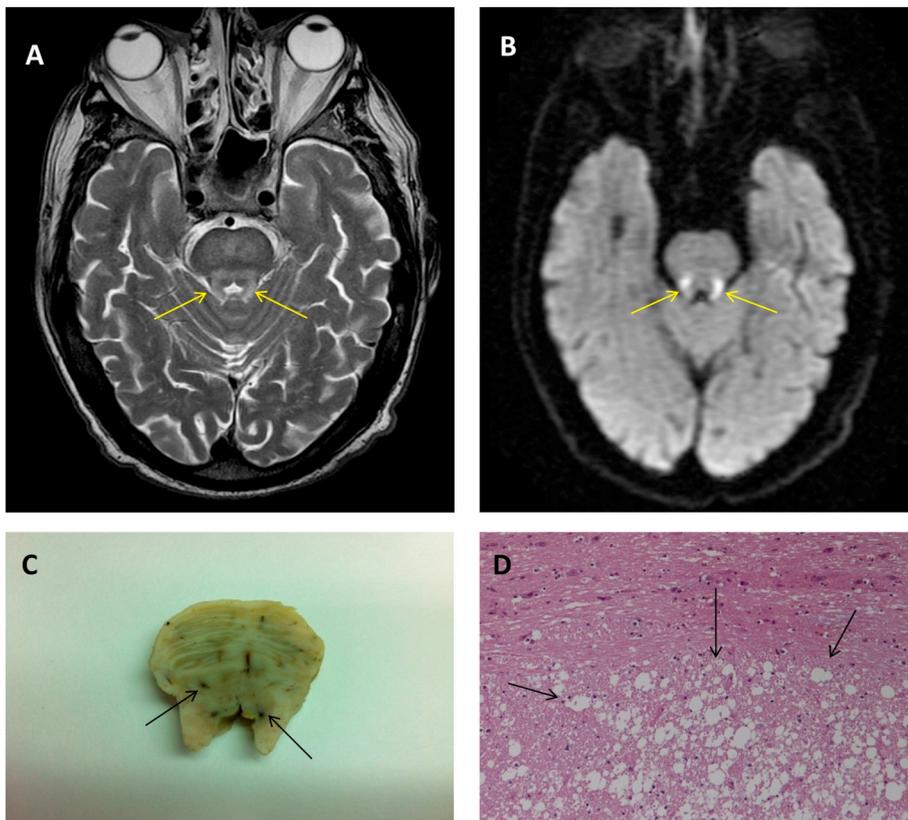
Brain magnetic resonance imaging axial sections and neuropathology sections.
